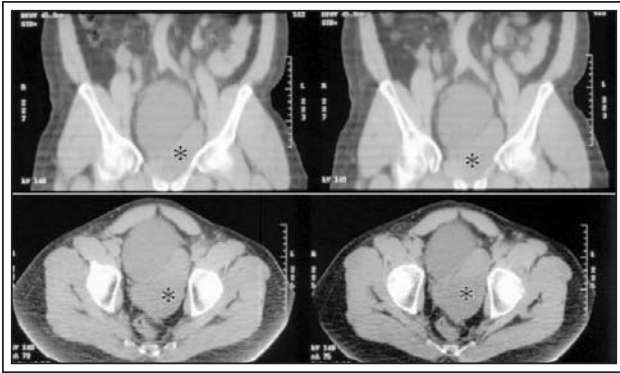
CT scan showing mass posterior and lateral to urinary bladder (asterisks).
